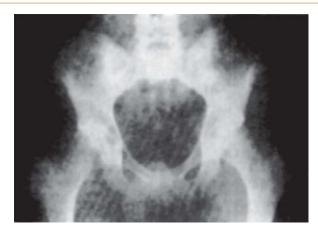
Radiograph of osteoarthritis of hip
